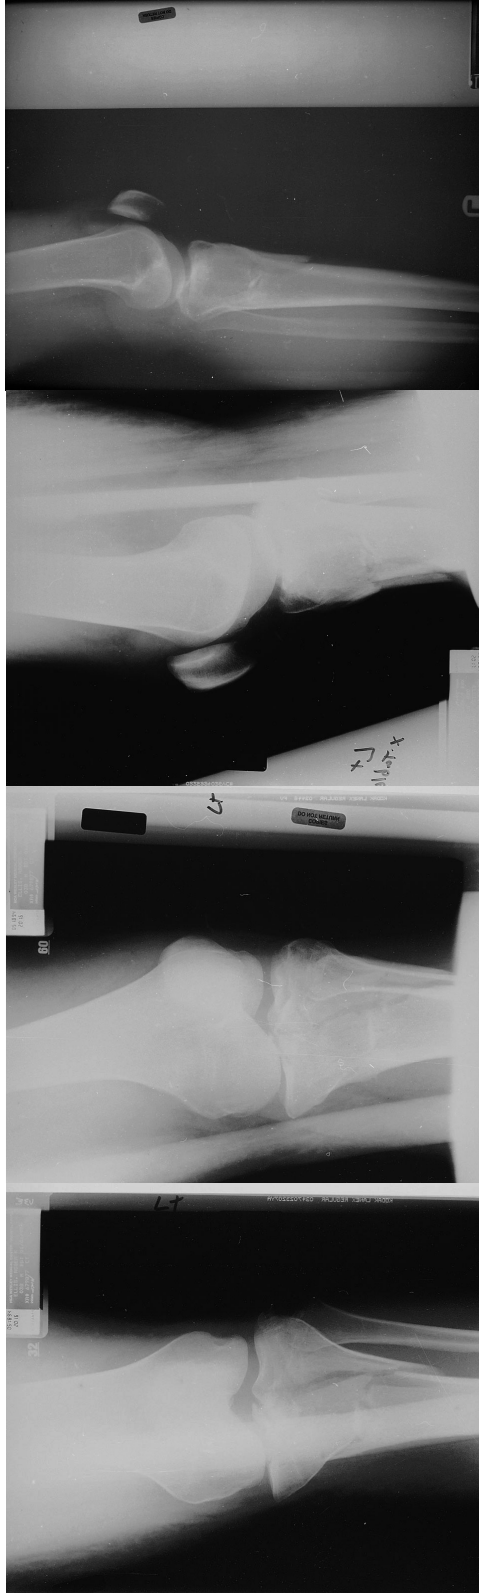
Radiographs from PWC File 4.
